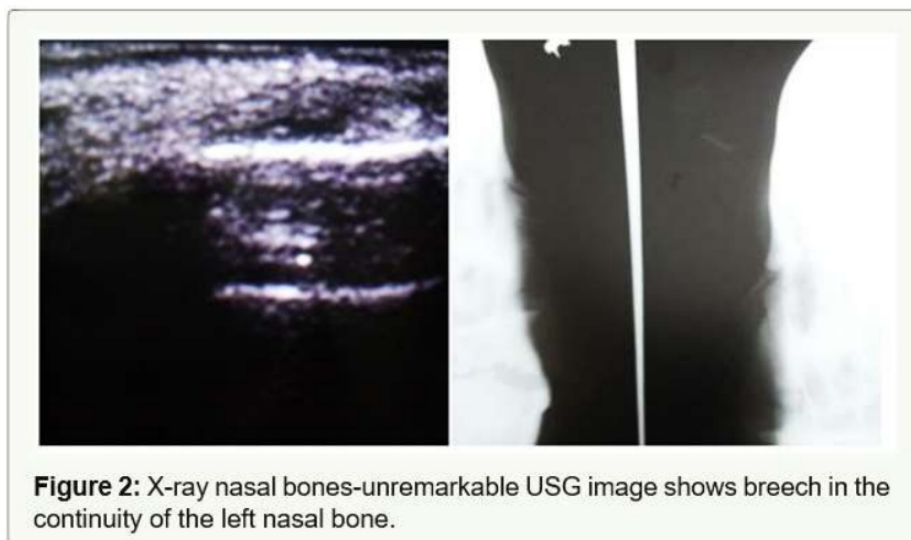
X-ray nasal bones-unremarkable USG image shows breach in the continuity of the left nasal bone.
